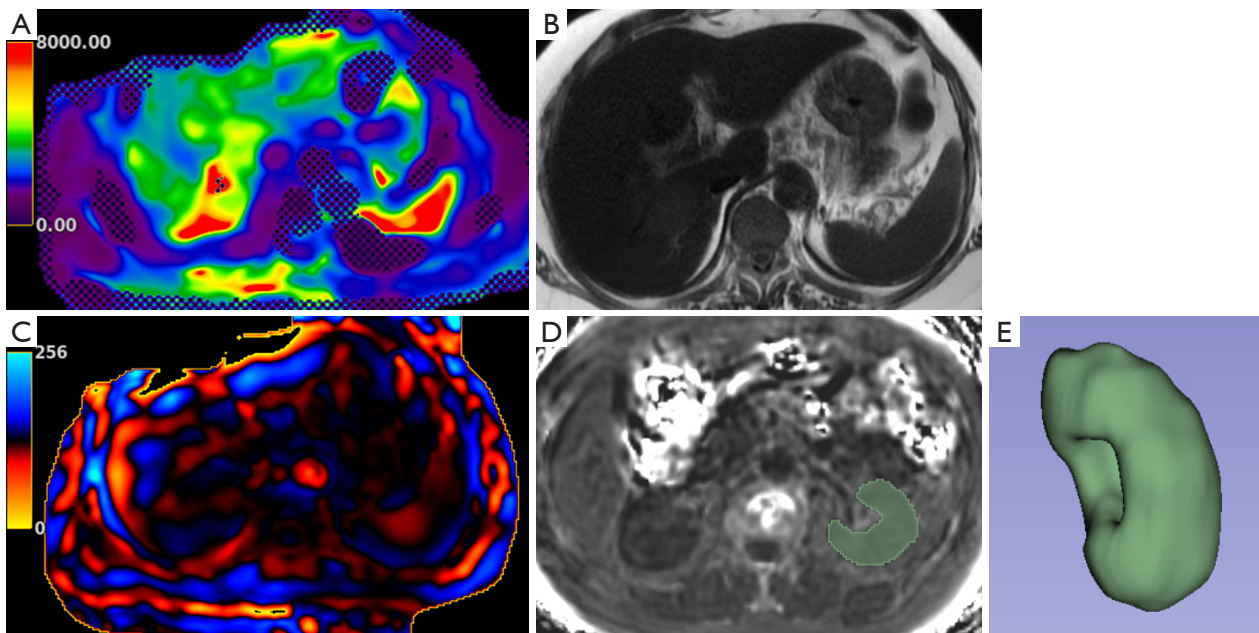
MRE in a 69-year-old male patient. (A) Color-coded liver elastogram with 95% confidence overlay, (B) axial T2-weighted image, (C) shear wave image, (D) axial R2* map with segmented left kidney (green), and (E) 3D rendering of the segmented left kidney. Liver stiffness measured 3.4 kPa on MRE. 3D, three-dimensional; MRE, magnetic resonance elastography.
